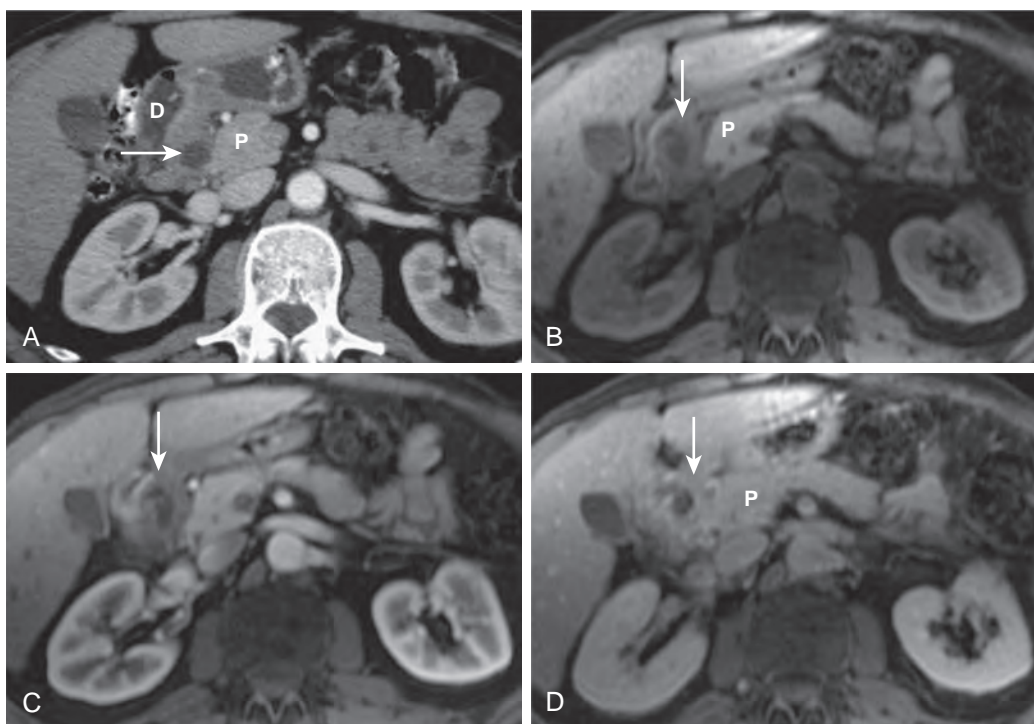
Groove pancreatitis. A. Axial contrast-enhanced MDCT shows hypoenhancing inflammatory tissue containing low-density cyst (arrow) in the groove between the duodenum (D) and the pancreatic head (P). B. Axial T1-weighted fat-suppressed spoiled gradient-echo MR image shows low signal intensity of the inflammatory mass (arrow) between the high signal intensity pancreatic head (P) and the duodenum. C and D. The mass (arrow) has decreased enhancement in the arterial phase (C) and delayed enhancement in the venous phase (D) after gadolinium administration because of fibrosis. (A-D from Miller FH, Keppke AL, Wadhwa A, et al: MRI of pancreatitis and its complications: Part 2, chronic pancreatitis. *AJR Am J Roentgenol* 183:1645–1652, 2004. Reprinted with permission from the American Journal of Roentgenology.)
